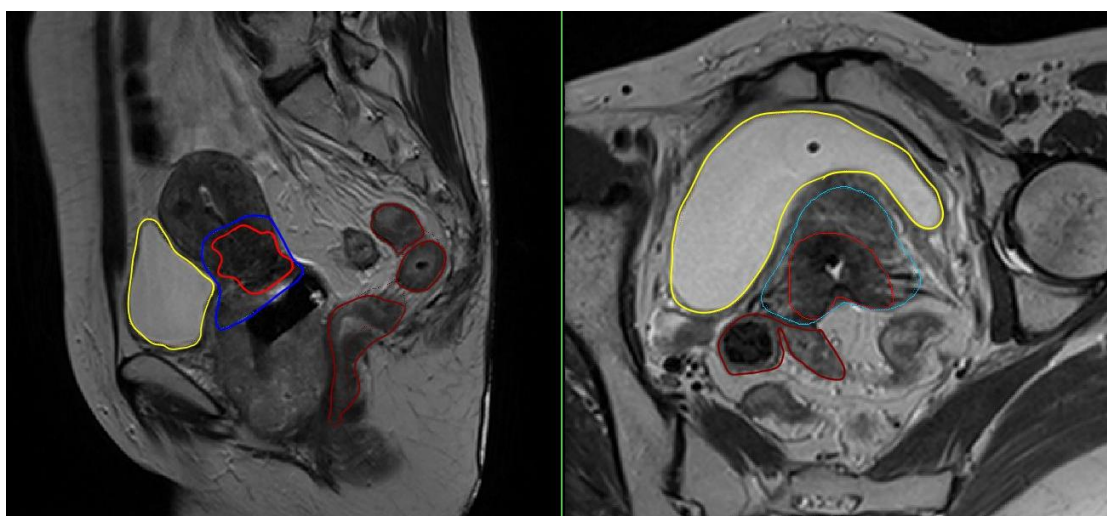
Sagittal and para-uterine MRI images with intrauterine tube and ring in-situ for cervical brachytherapy. HR-CTV (red), IR-CTV (blue), bladder (yellow) and rectum (maroon) outlined.
